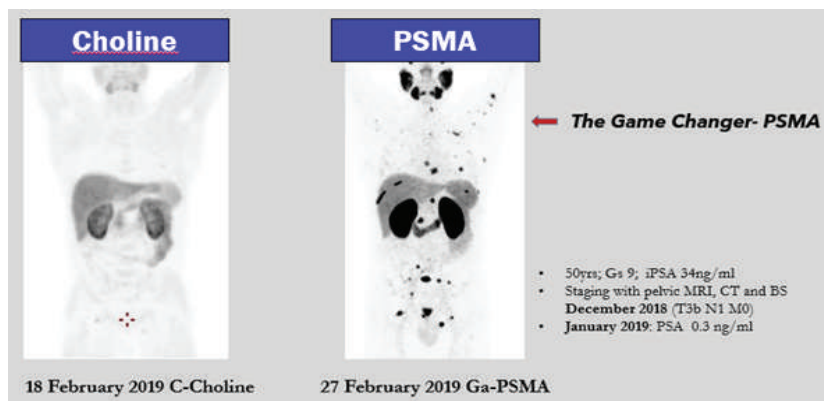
Compared to conventional imaging techniques, PSMA PET scans provide improved tumor detection and localization, marking a substantial progress in prostate cancer imaging. By using prostate-specific membrane antigen (PSMA) as a target, this method improves the precision of detecting malignant tumors. Because PSMA PET scans enable more accurate therapy targeting and better patient results, they are considered a revolutionary technique in the management and treatment of prostate cancer.
